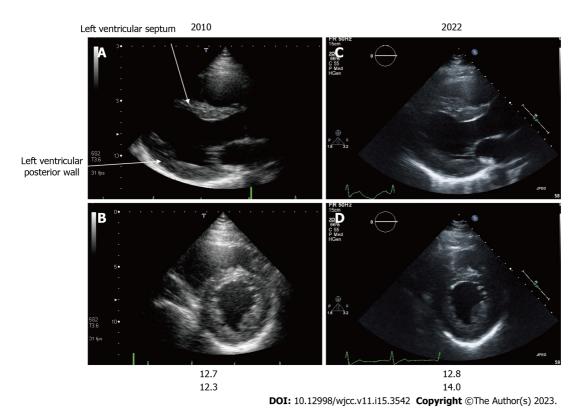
Echocardiography findings of Case 2. A and C: Long-axis image; B and D: Short-axis image; A and B: Images of patient 2 at 39 years of age; C and D Images of patient 2 at 52 years of age. The echocardiographic findings of the left ventricular septum and left ventricular posterior wall thickness of patient 2 are shown at 39 (A and B) and 52 (C and D) years of age. A change suggestive of asymmetric ventricular septal hypertrophy was observed at 39 years of age. There was a minor progression in ventricular hypertrophy in the left ventricular septal thickness and left ventricular posterior wall thickness 13 years following enzyme replacement therapy initiation.
